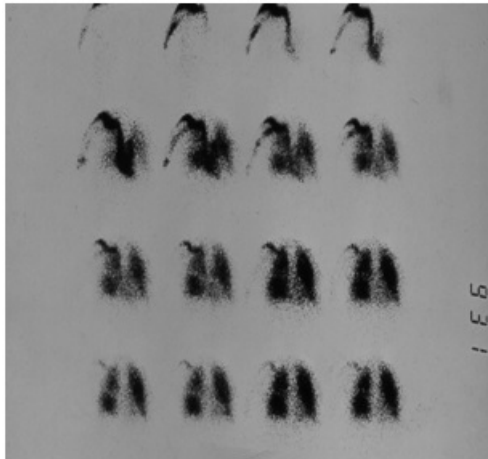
Lung scan scintigraphy 3 months later
